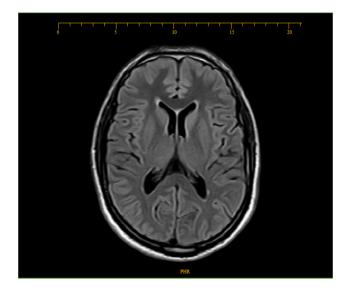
MRI brain revealing normal findings.
